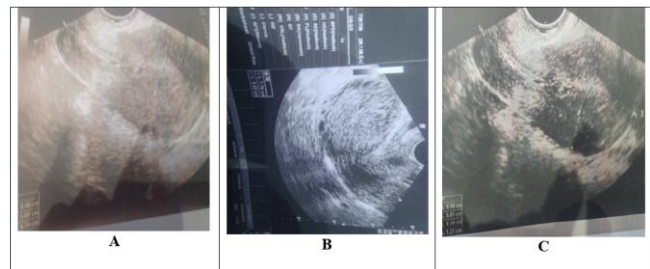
Showed ultrasound images of hyperplasia lesions when the endometrium measures A) 13mm B) 12 mm, and C) 12.7 mm.
